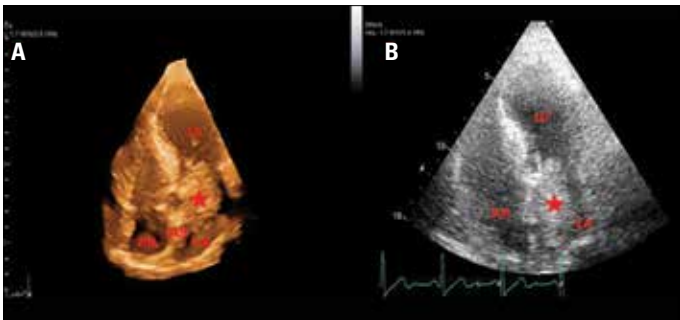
A) Two- and B) three-dimensional transthoracic echocardiographic examination detected a large mass occupying almost the entire the left atrium
